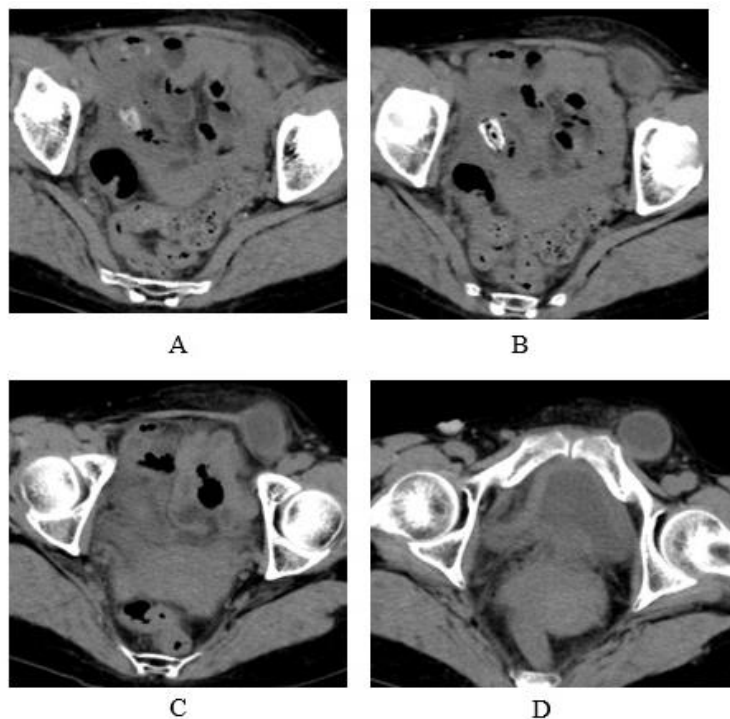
A cystic lesion with mural thickness is depicted on axial CT. The lesion is adjacent with bowels that are not dilated. It indicates no evidence of small bowel ileus.
